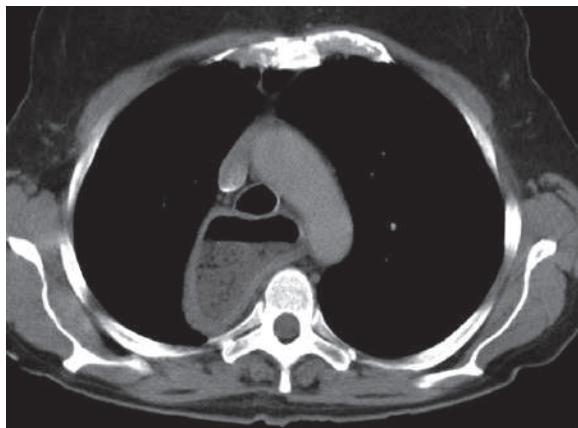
Axial thoracic CT in a patient with chronic Chagas' disease shows massive dilatation of the esophagus, with food lodged inside the esophagus, mimicking achalasia
